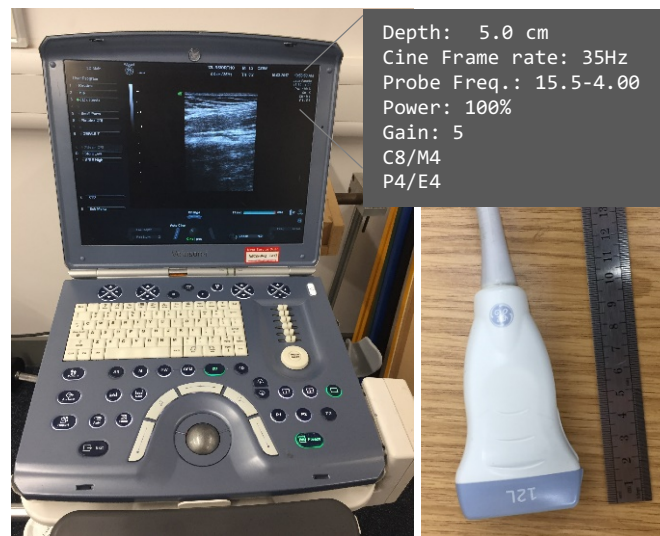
Ultrasound machine settings and probe transducer
